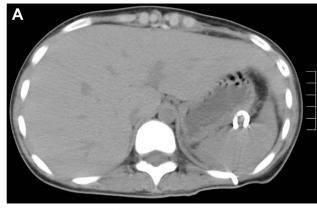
Contrast-enhanced computed tomography images of the abdomen revealing multiple splenic abscesses and a perisplenic abscess. (A) A large amount of perisplenic abscess enveloped posterior to the medial portion of the upper pole of the spleen and (B,C) finally communicated with the abscess located adjacent to the hilum of the spleen (3.5 cm; thin arrow in B and C). Ring enhancement was found in the abscess near the posterior chest wall (4.0 cm; thick arrow in C).
